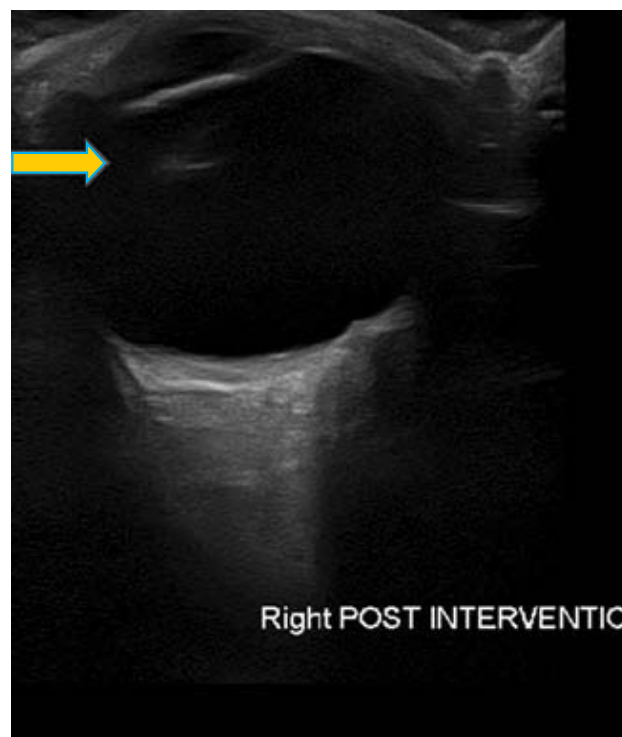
Post-operative ultrasound shows successful removal of foreign body followed by new intraocular lens placement.
